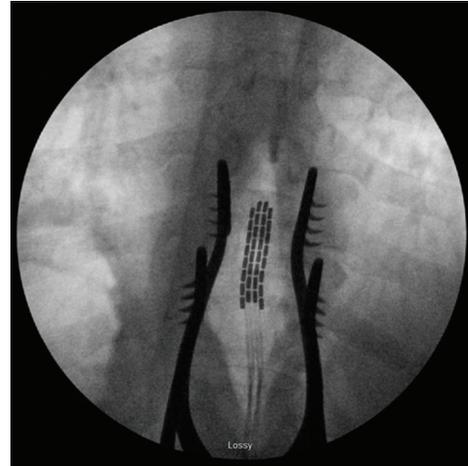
Intraoperative radiograph demonstrating repositioning of the paddle to the T10–T11 vertebral level.
